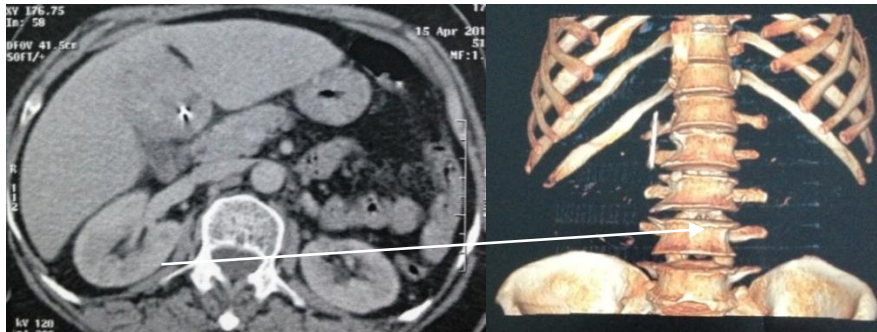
CT angiography which objectified a heterogeneous hypodense formation at IVb segment centered by a calcium density artefact, the reconstruction image shows the foreign body (arrow).
